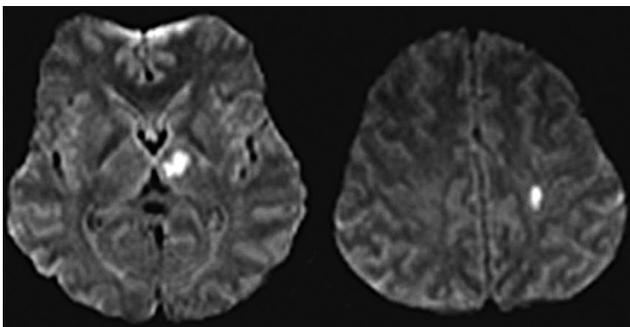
Axial MRI diffusion weighted imaging on the first stroke shows acute infarcts over the left thalamus and left centrum semiovale.
